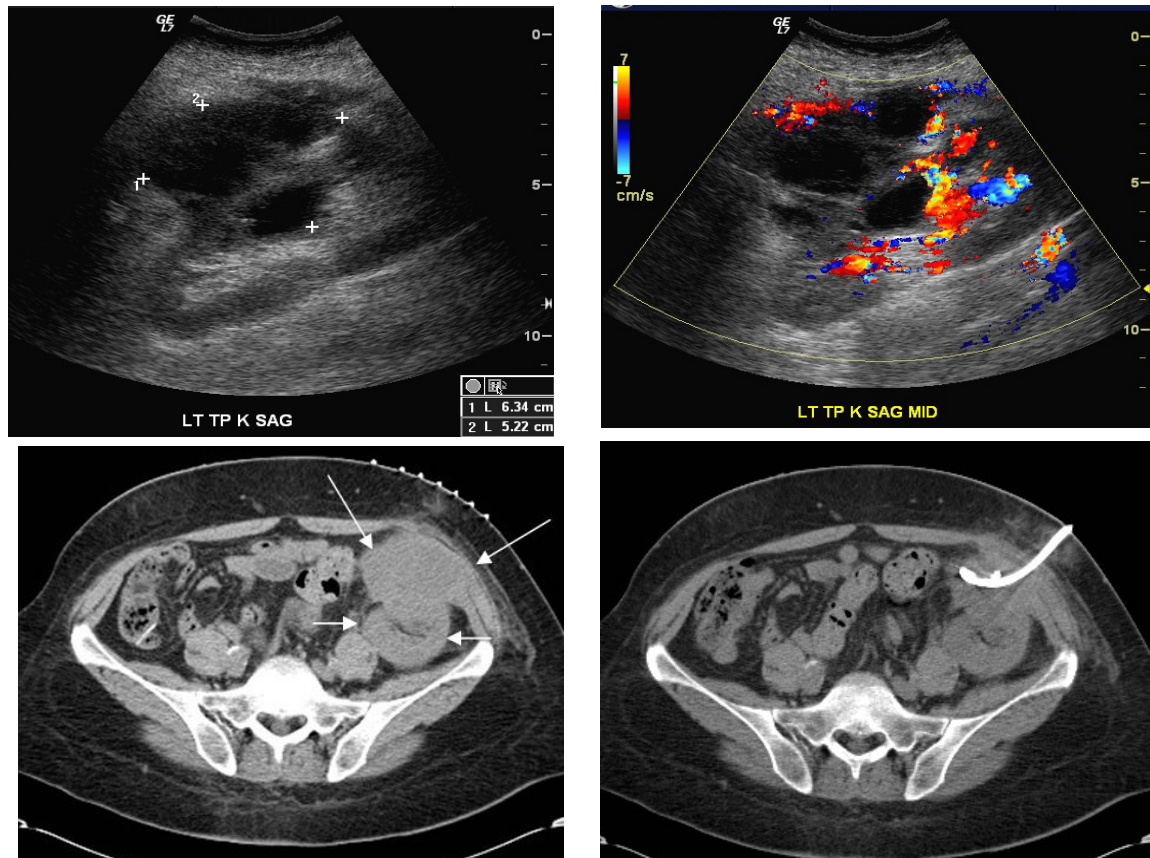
Renal Abscess. (A) is a gray scale sagittal image through the transplant kidney that shows an exophytic multi-septated abscess (calipers). (B), a color Doppler image of the same area shows peripheral vascularity without any significant internal flow. (C), an axial CT scan image through the pelvis shows transplant kidney (short arrows) with the abscess protruding anteriorly (long arrows). (D) shows a drain placed in the abscess.
